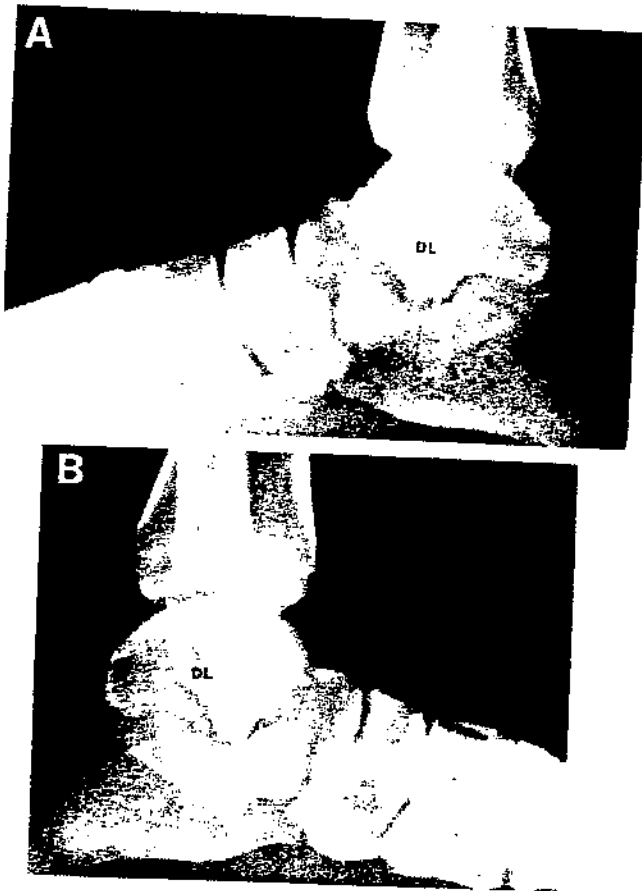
Lateral weightbearing radiographs of the injured right foot (A) and normal left foot (B) of the same patient as in Figure 2. Note that there is no collapse of the midfoot.
